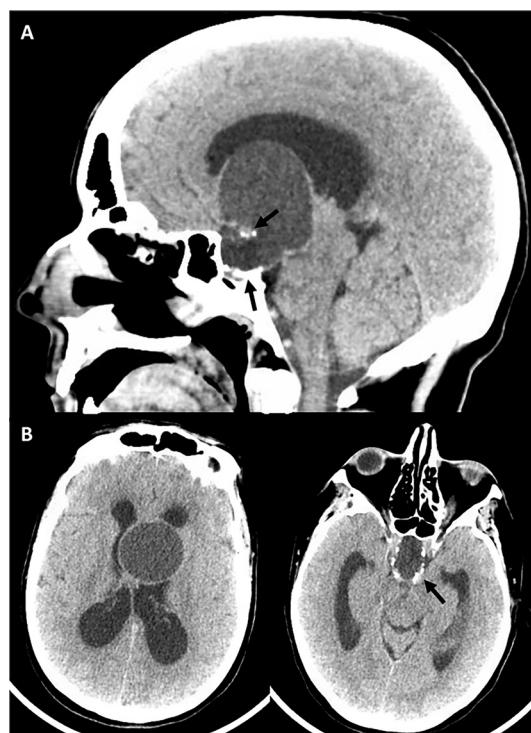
Sagittal (A) and axial (B) sections of CT scan of the head demonstrate a cystic mass lesion with peripheral calcification (black arrows), measuring 6.0×4.5×3.9 cm, originating from the pituitary gland, expanding into the suprasellar cistern, interpeduncular cistern and distorting the floor of the third ventricle with significant compromise of foramen of Monroe, resulting in bilateral ventricular dilatation.
